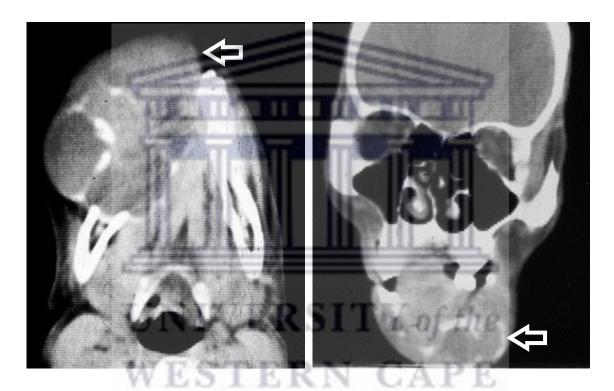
Axial and coronal CT showing destructive, ill-defined primary intraosseous odontogenic carcinoma arising from residual cyst.
